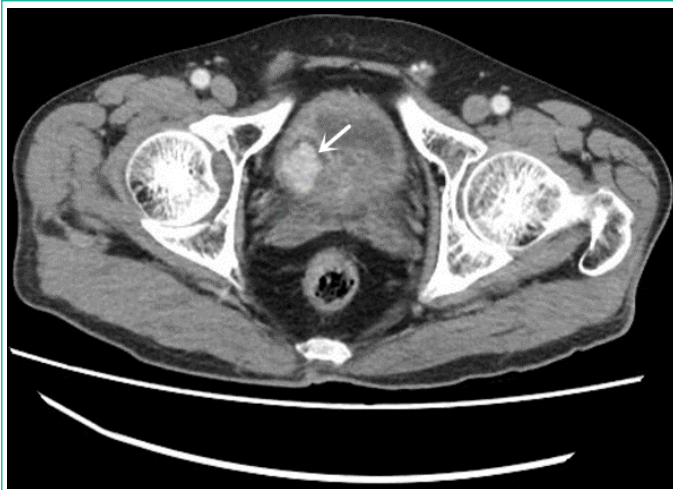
Intensified CT image of the abdomen (White arrow, the bladder occupancy shows significant enhancement after enhancement).
